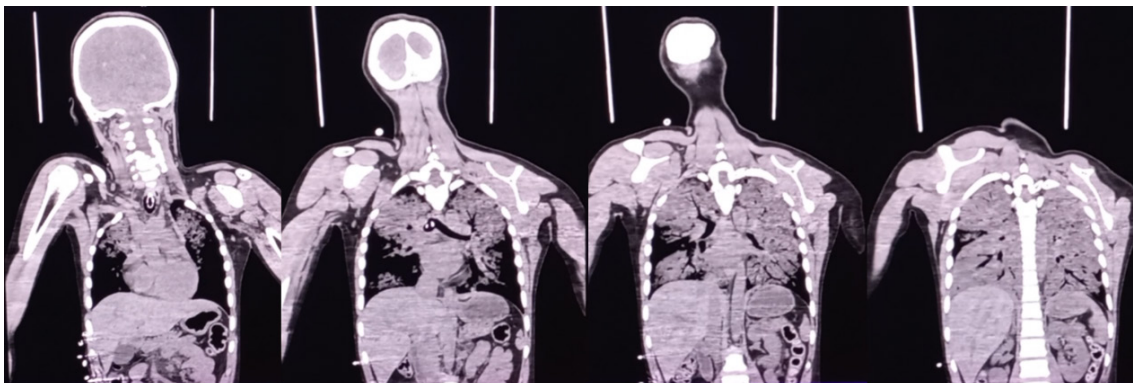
CT chest (anterior to posterior) revealing diffuse ground glass opacities in bilateral lung fields with sparing of few areas of anterior, middle, and posterior segments of right upper lobe and anterior and lingular segments of left lobe, suggestive of pulmonary edema
